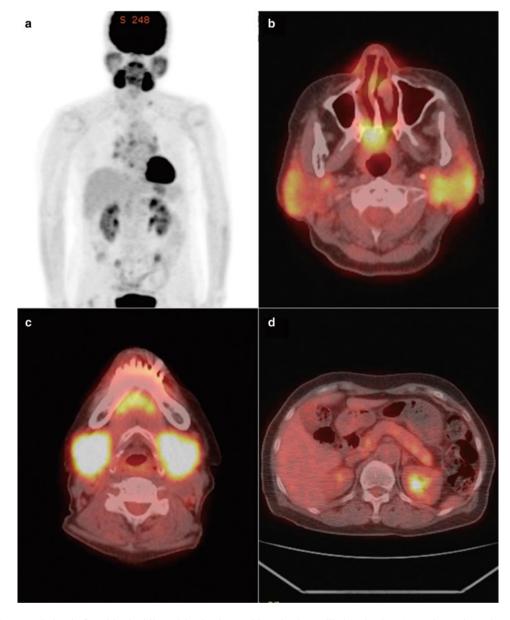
FDG accumulation is found in the bilateral lacrimal, parotid, and submandibular glands. (a) Maximum-intensity projection image; (b–d) PET-CT fusion image
